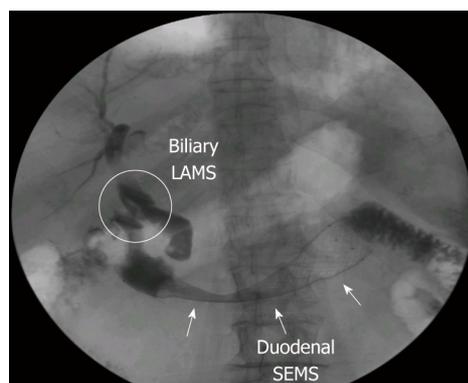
Radiological features of a lumen-apposing metal stent placed with endoscopic ultrasonography choledoco-duodenostomy with a duodenal self-expandable metal stent in a synchronous bilio-duodenal stenosis. LAMS: Lumen-apposing metal stent; SEMS: Self-expandable metal stent.
